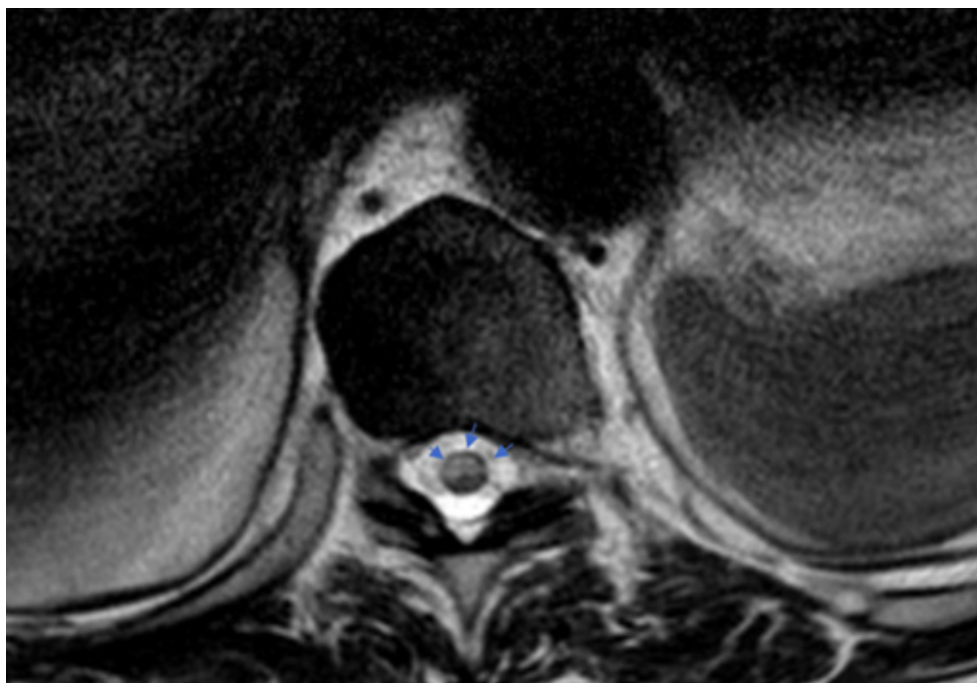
Thoracic magnetic resonance imaging: T2-weighted axial sequences showing hyperintensity in the anterior portion of the spinal cord (blue arrows) at the T11 segment, consistent with spinal cord infarction.
